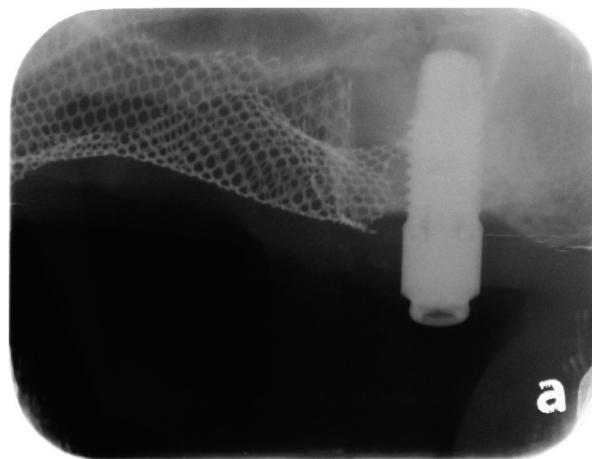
Periapical film of the implant at the three-year follow-up.
